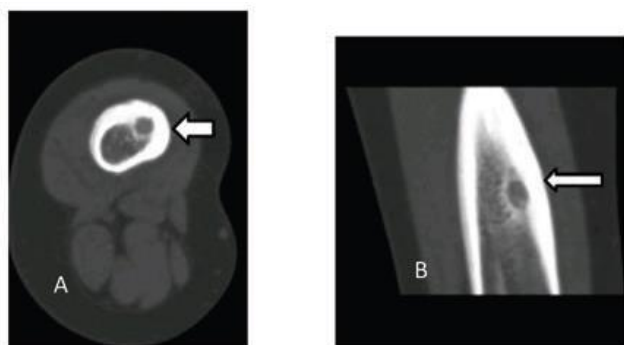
CT of an osteoid osteoma of the femur (A axial, B coronal), indicated by arrow [75]
